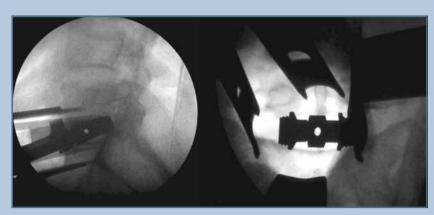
Trial implant selection under X-ray image intensifier control (lateral and frontal views)
